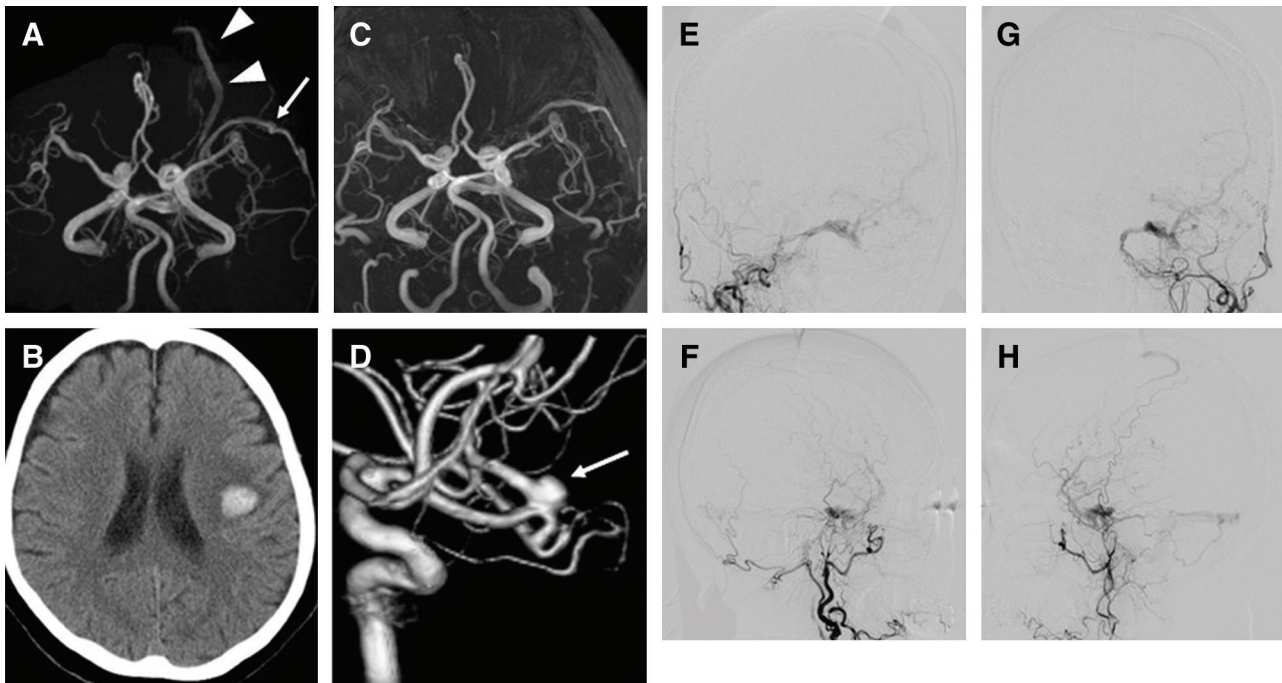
Preoperative MR angiography, brain CT, DSA. MR angiography revealed CS-dAVF accompanied by an expanded left SOV (arrowheads) and left SMCV (arrow) (A). Brain CT showed a small parenchymal hematoma in the left temporal lobe (B). The left SOV was not depicted by MR angiography (C). Three-dimensional DSA of the left internal carotid artery showed a 7-mm broad-neck uAN at the left MCA M1/M2 junction (arrow) (D). A right external carotid angiogram A-P view and lateral view (E, F). A left external carotid angiogram (G: A-P view, H: lateral view). A bilateral external carotid angiogram showed right CS-dAVF. CS-dAVF: cavernous sinus dural arteriovenous fistula, CT: computed tomography, DSA: digital subtraction angiography, MCA: middle cerebral artery, MR: magnetic resonance, SOV: superior orbital vein, uAN: unruptured aneurysm.
